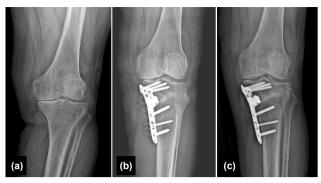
Anteroposterior (AP) radiographs of a patient with combined autograft and allograft. a) Preoperative AP radiograph; b) Early postoperative AP radiograph with autograft+allograft; c) Late postoperative AP radiograph with autograft+allograft.
